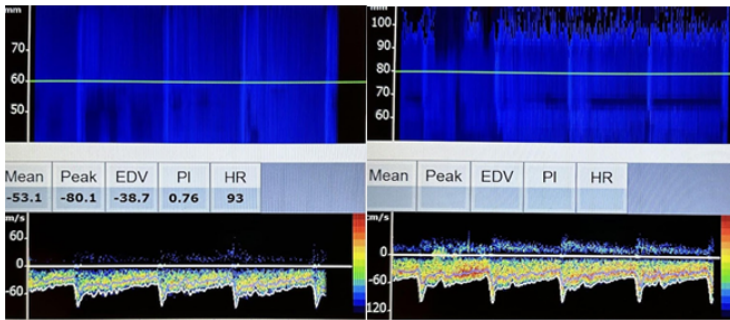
Side-by-side velocities and flow patterns of the left vertebral artery and basilar artery on transcranial Doppler.
